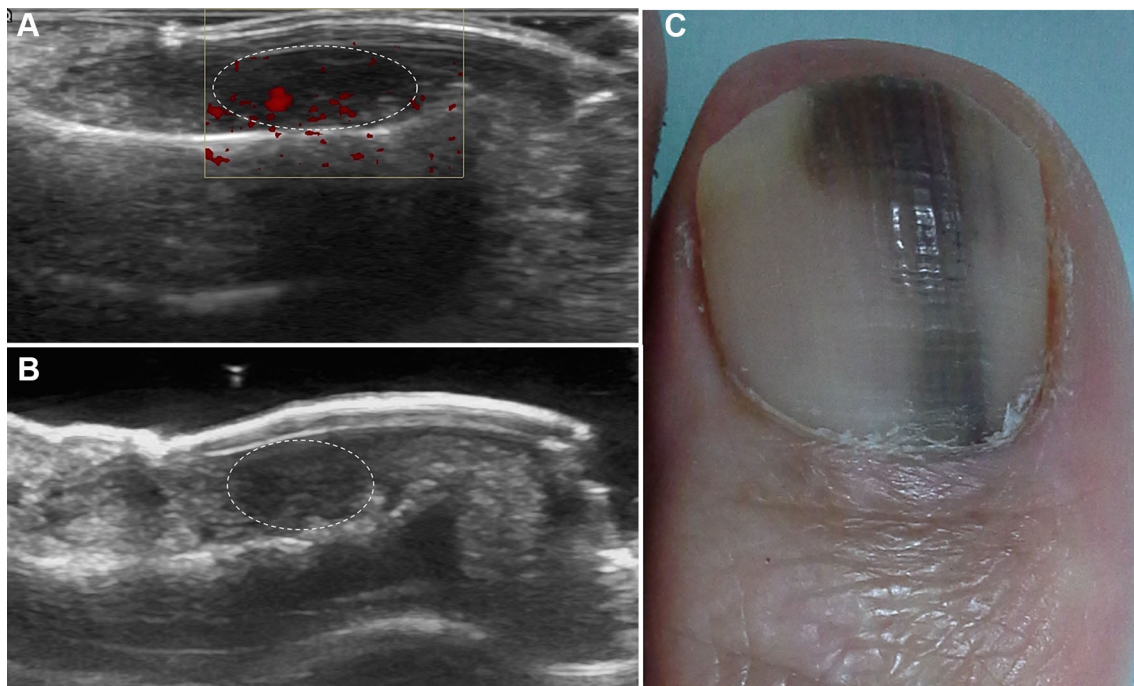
Melanoma. Ultrasound a longitudinal and b transverse views. Hypoechoic, ill-defined, hypervascular mass in the middle third of the nail bed (*pointed line*), corresponding to melanoma in a patient with melanonychia. c Patient with melanonychia corresponding to melanoma
